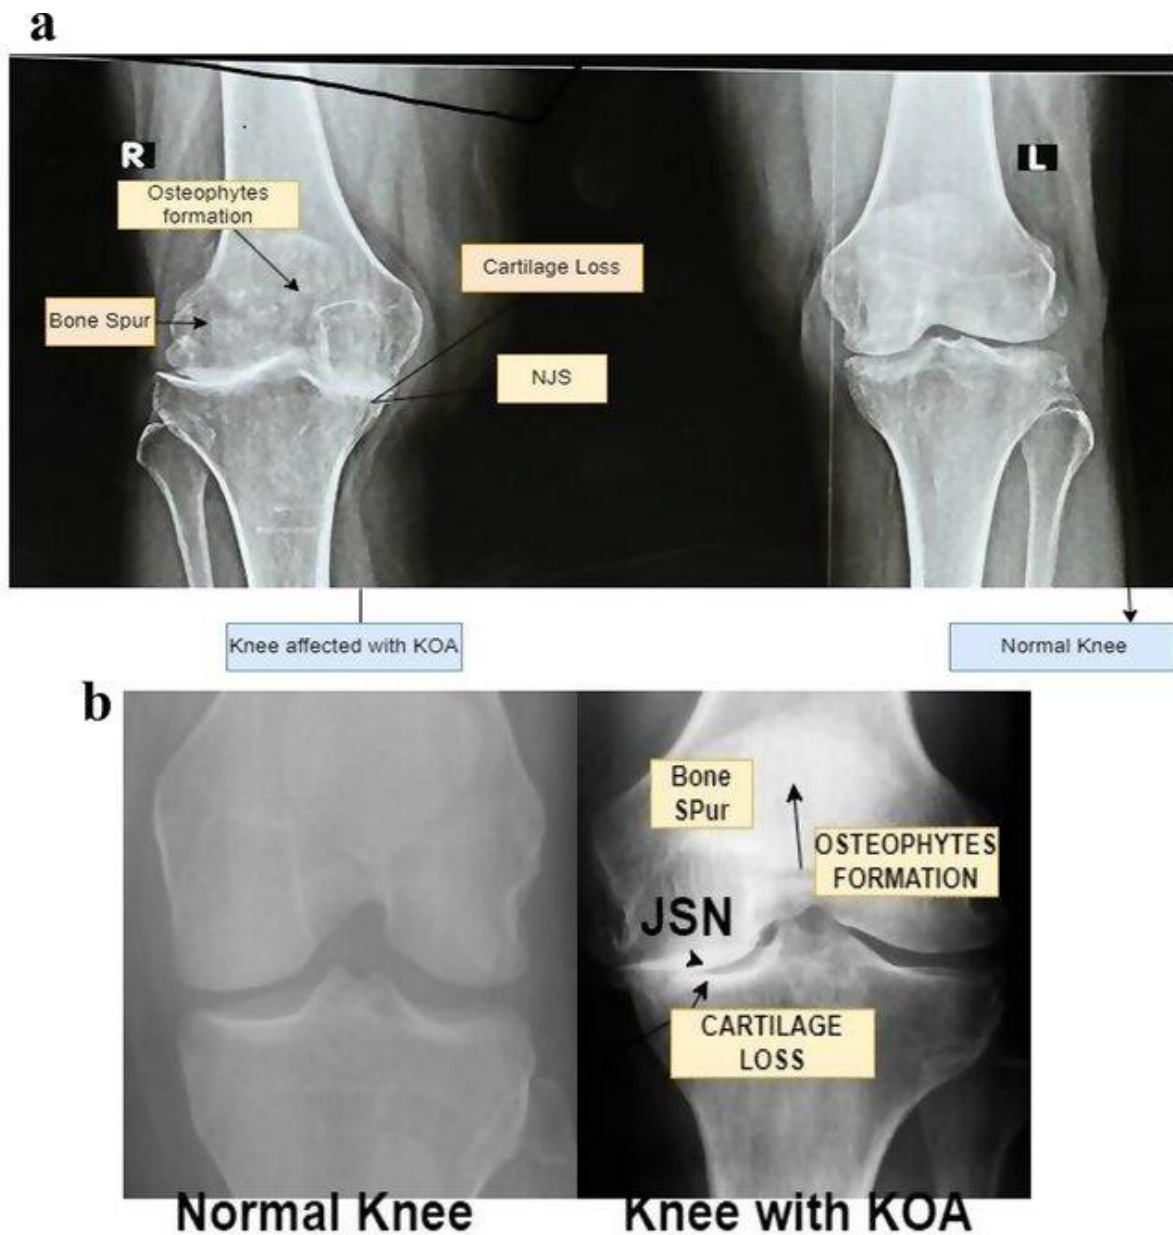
X-ray descriptions of the normal and OA knee.³⁶
